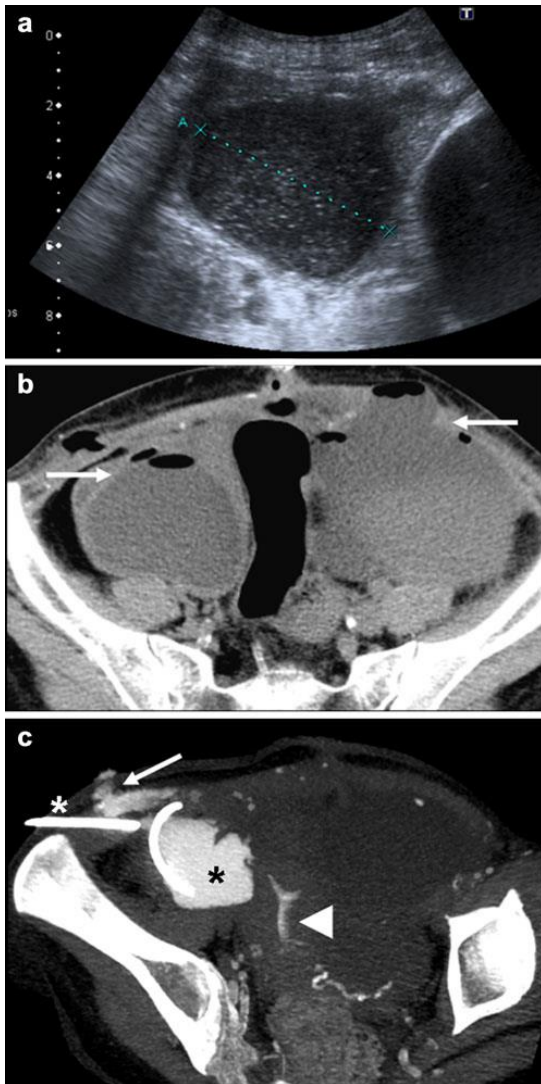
A 30-year-old woman after SPK transplantation. a Abdominal ultrasound shows peri-pancreatic graft collections with a thick wall and echogenic content; b axial MDCT reveals multiple abscesses at the abdomen and pelvis, with extension to the abdominal wall. Ultrasound-percutaneous drainage was performed and chemical analysis of the fluid showed high amylase content, compatible with a pancreatic fistula. c A 3D-MPR MIP reconstructed from follow-up MDCT performed 3 days later, with introduction of iodinated contrast agent through the percutaneous drain (*white asterisk*), demonstrates the extension of intra-abdominal collection (*black asterisk*) and the fistulous tract to the abdominal wall (*arrow*). Contrast agent was also detected inside the uterine cavity (*arrowhead*) suggesting a fistula. Despite this complication, the pancreatic and renal grafts functioned normally
